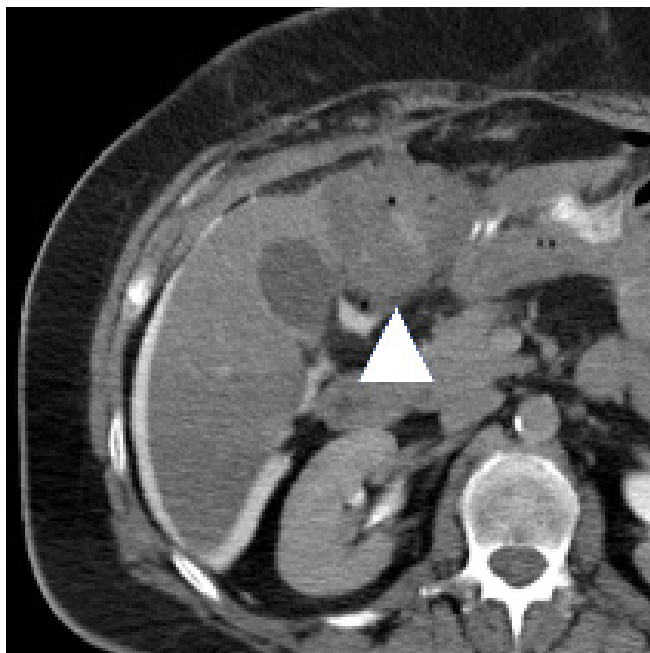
Intraprocedural noncontrast computed tomography image demonstrates 1 microwave probe within the lesion, with the tip pointed toward the gastric antrum. A protective buffer (arrows) was created with injection of a 20:1 mixture of dextrose (D5W) and nonionic contrast (radioopaque material) between the mass and the gastric antrum (arrowhead).
